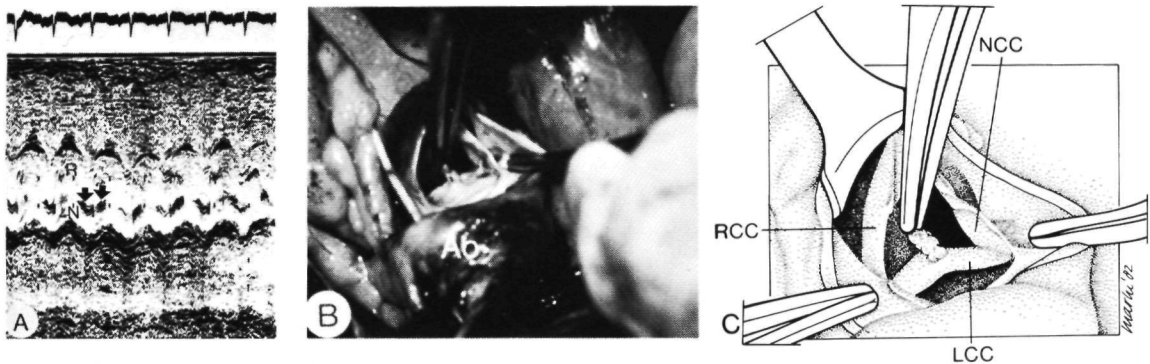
Echocardiogram and operative finding in case 43.
